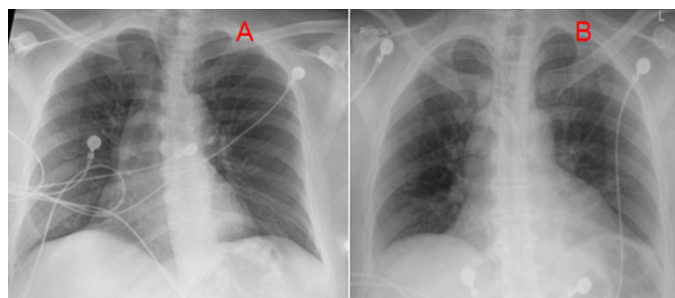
Chest X-ray of (A) pre- and (B) post-laminectomy and decompressive surgery of SSEH. (1A) Normal chest X-ray. (1B) Minimal left side basal atelectasis.
